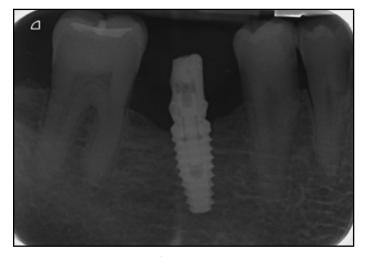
Radiograph of crown abutment.
